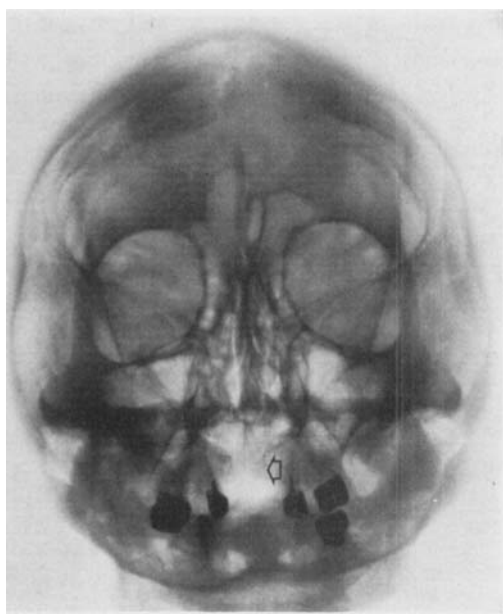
Skull. Roentgen examination. AP view. Note the cleft palate (arrow).
